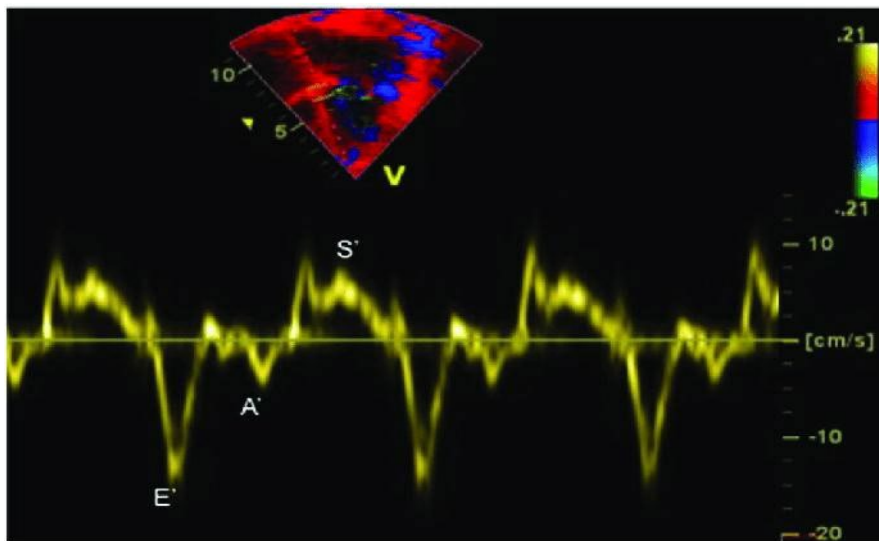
Tissue doppler imaging
